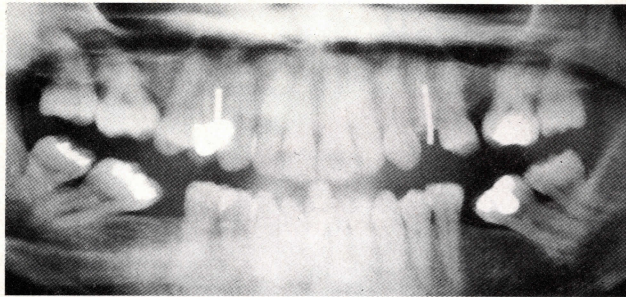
Preorthodontic panoramic x-ray, showing the absence of first molars in all quadrants. All four quadrants exhibit varying degrees of molar collapse, edentulous space, and angular crest formation.
